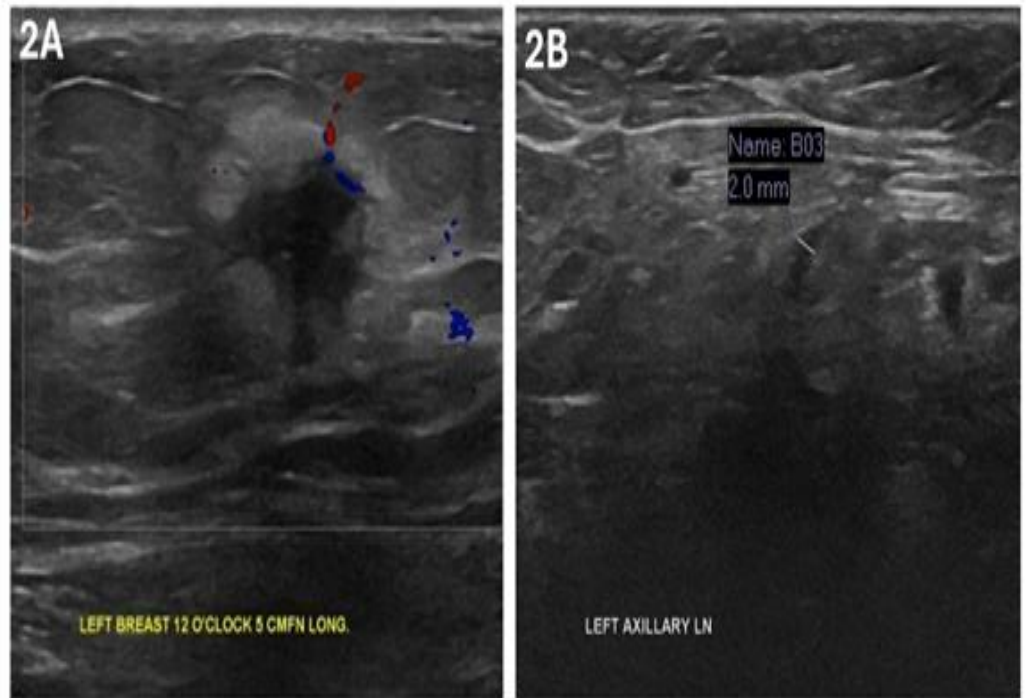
Figure 2A: Breast ultrasound of the left breast showing a hypoechoic, irregular lesion with spiculated margins, echogenic halo, and peripheral vascularity.
